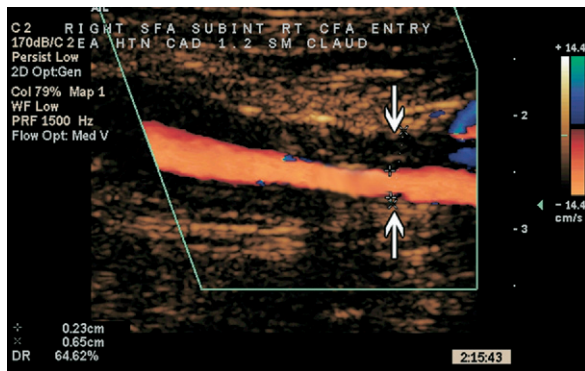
Intraoperative color Doppler image of the recoiling plaque in the superficial femoral artery causing 64.6% stenosis (between the *white arrows*).
